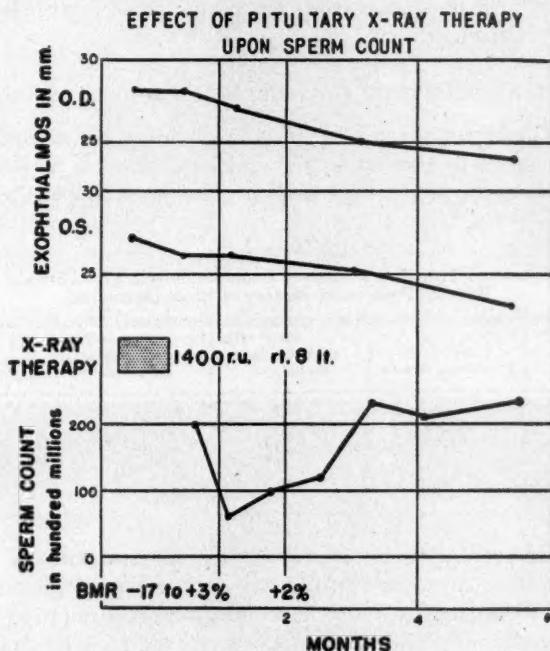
Note the effect of roentgen therapy to pituitary upon the sperm count, used as an assay method. The effect apparently disappeared within two months.
